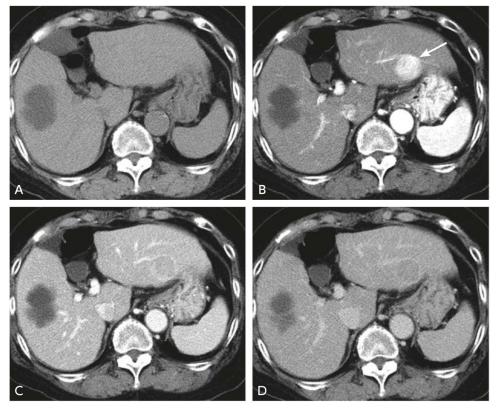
Multiphase contrast-enhanced CT (moderately differentiated hepatocellular carcinoma)
